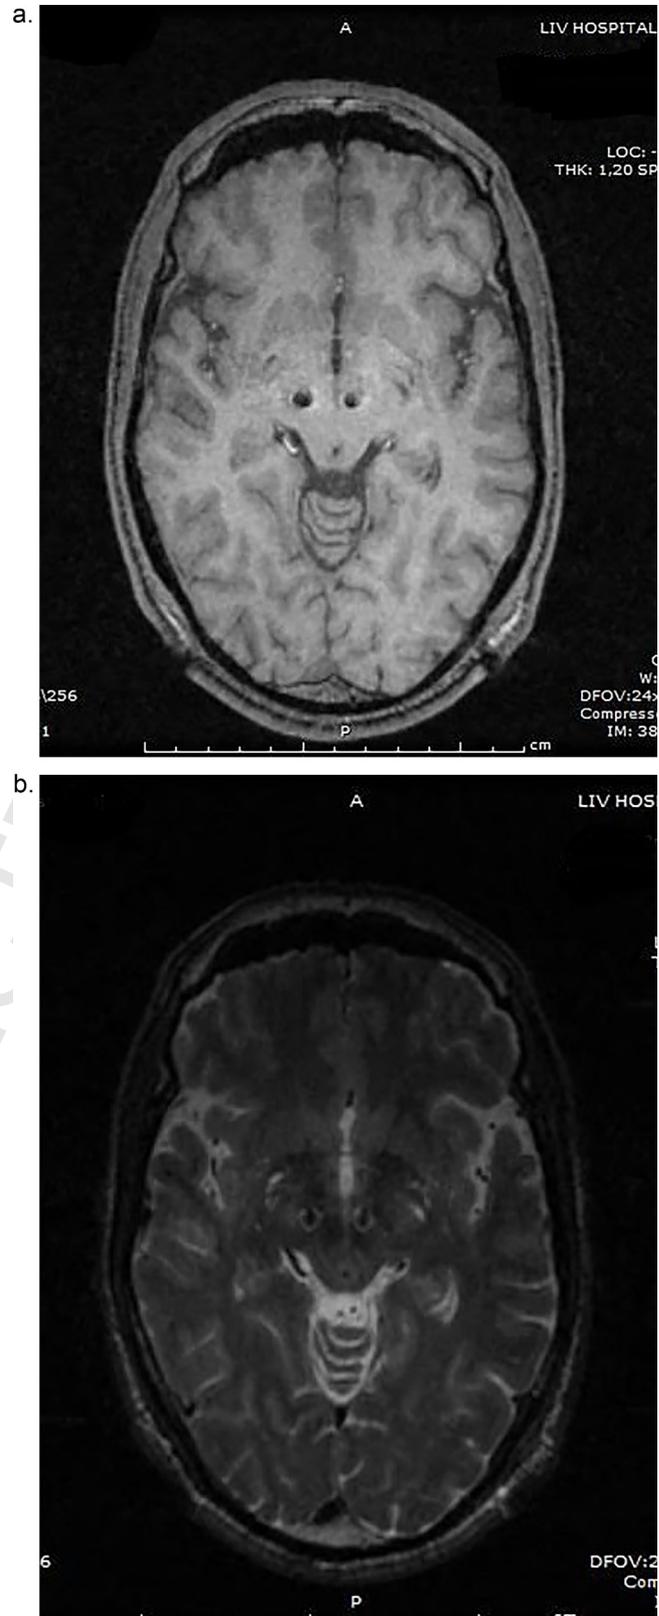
(a) and (b) Control MRI scan showed that the position of the depth electrode is appropriate on the right side, however too much medially located in the left side as shown by the axial T1 (a) and T2-weighted (b) images.
